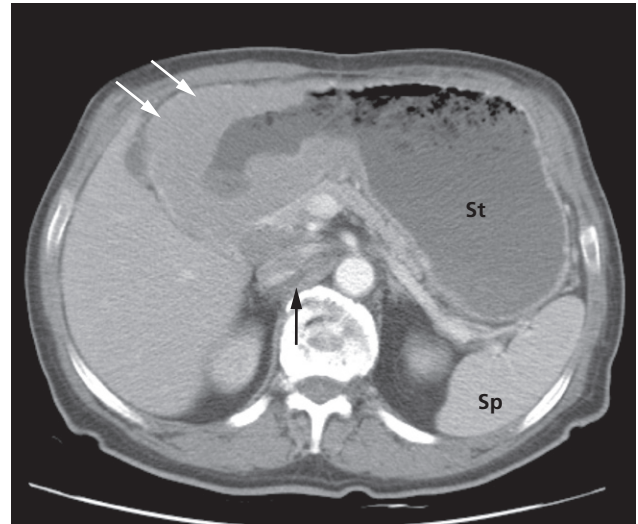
Gastric lymphoma in the antrum, demonstrated on CT (white arrows). Lymphadenopathy surrounds the inferior vena cava (black arrow). St, stomach; Sp, spleen.
